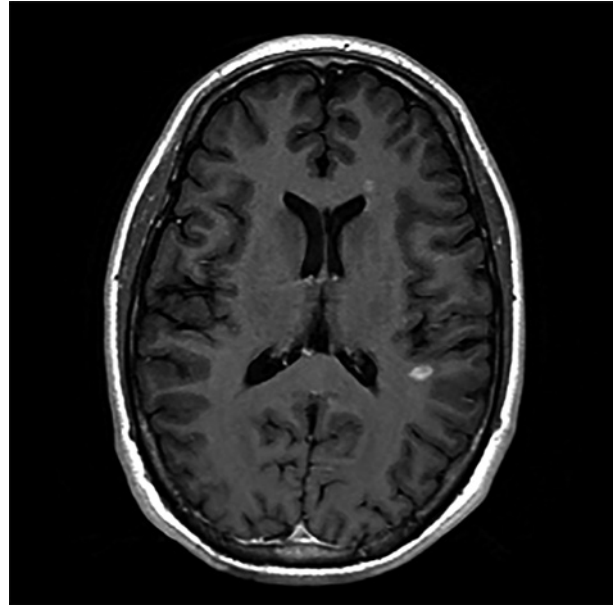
Axial T1-weighted MRI showing contrast enhancement of a characteristic white matter lesion in a patient with multiple sclerosis.
